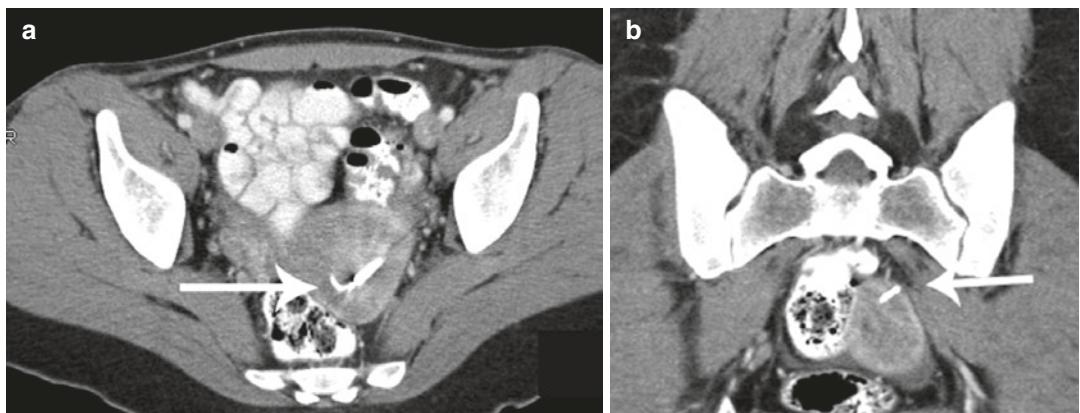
(a) Axial CT image of the pelvis with oral and IV contrast in a 42-year-old woman who presented for evaluation of mid-abdominal pain with an IUD present (arrow). (b) Coronal CT image shows that the IUD is embedded in the myometrium of the uterus extending to
